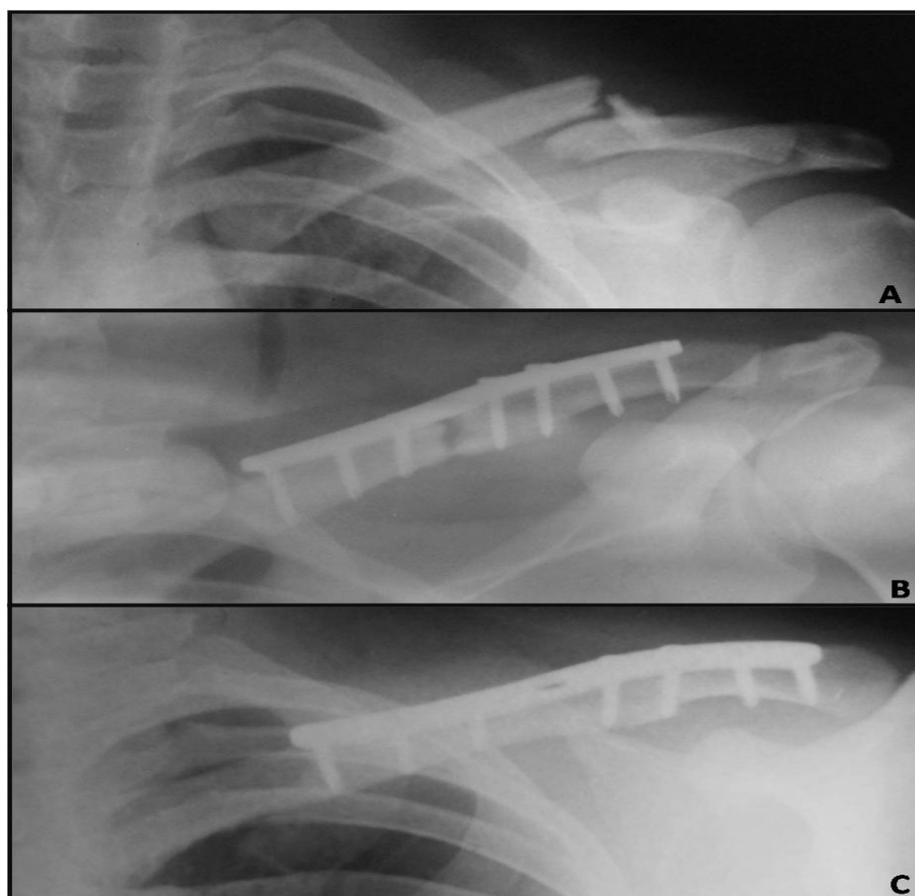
Preoperative (A), immediate postoperative (B) and one year postoperative (C) x-rays.
